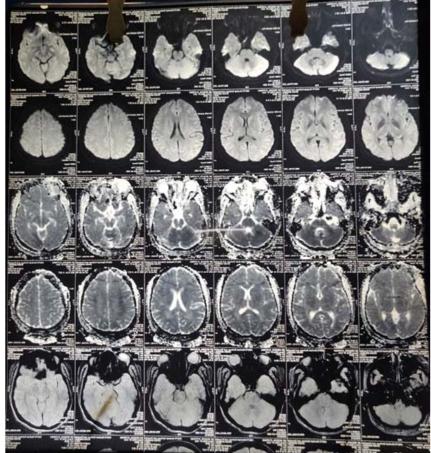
MRI Brain suggested meningitis
